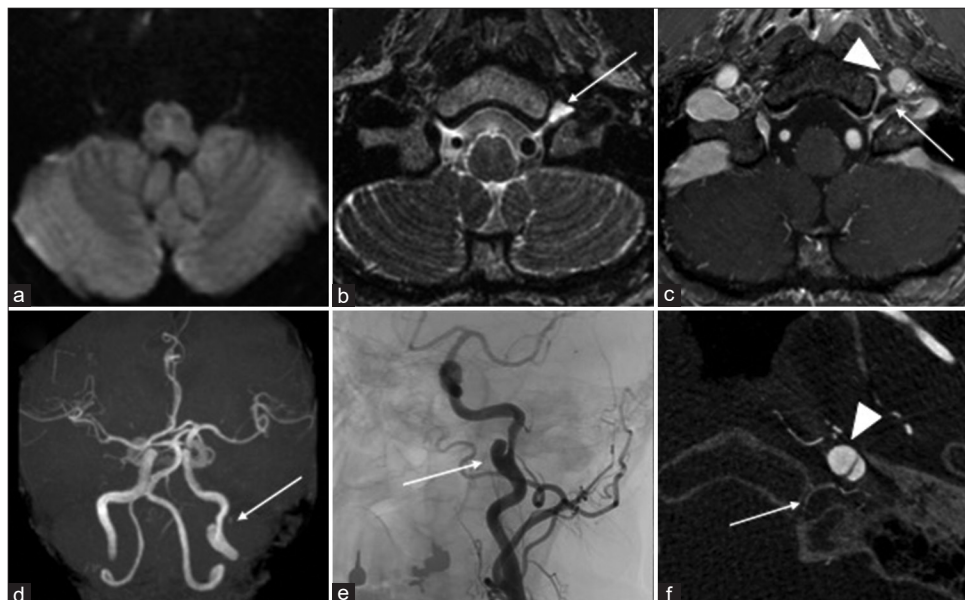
(a) Diffusion-weighted MRI showing no lesion in the medulla oblongata including the hypoglossal nerve nucleus. (b) T2-CUBE MRI showing false lumen of ICAD compressing the hypoglossal nerve tube, and the perineural space in the left hypoglossal canal is dilated (arrow). (c) T1-weighted MRI with contrast-enhancement showing dissected false cavity (arrowhead) compressing the distal side of the hypoglossal canal (arrow). (d) MRA showing a left ICAD with a false lumen (arrow). (e) Angiography showing a left ICAD (arrow). (f) Cone-beam CT showing that the false lumen (arrowhead) is protruding to the direction of the hypoglossal canal (arrow). Direct compression is thought to be causing hypoglossal nerve palsy.
